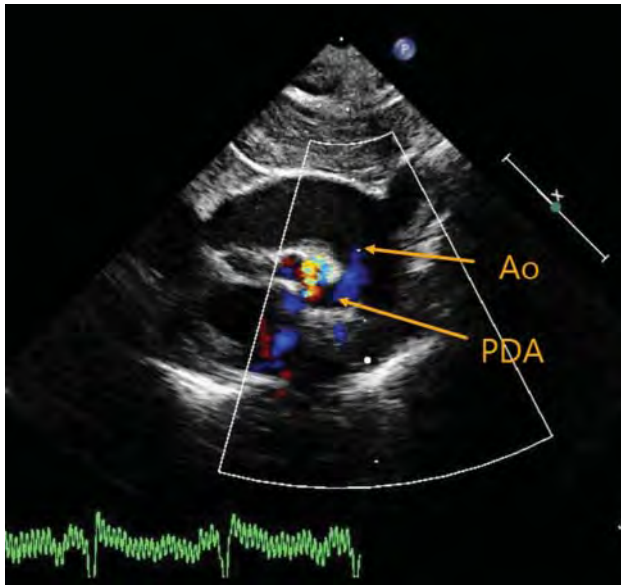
Suprasternal echocardiographic view of the aortic arch (Ao) and a PDA in a patient with a ductal dependent cyanotic heart defect. The PDA is tortuous and has a cranially directed concavity (“reverse-oriented” PDA).
